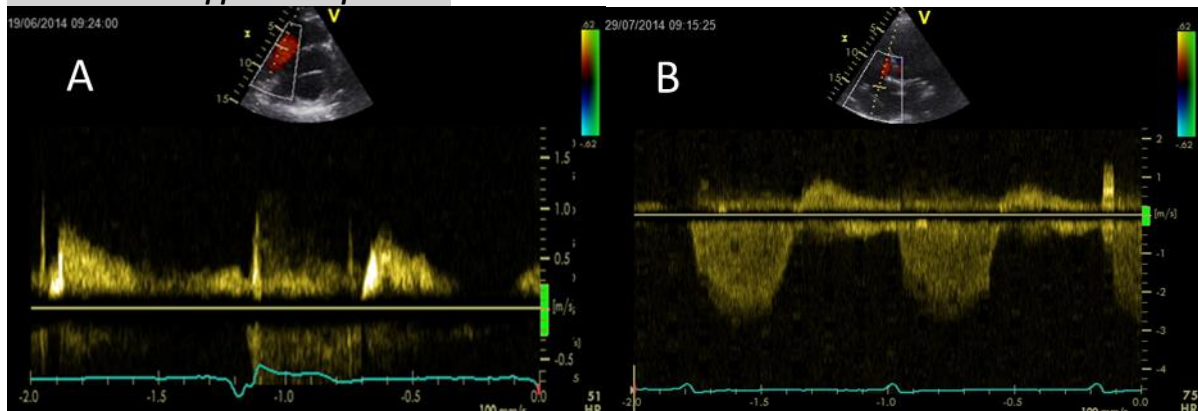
Color Doppler tricuspid valve
